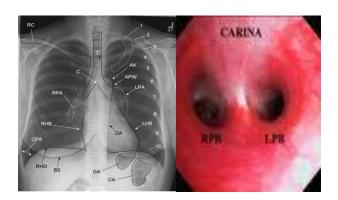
Radiographic view and bronchoscopic view of angle of carina.
